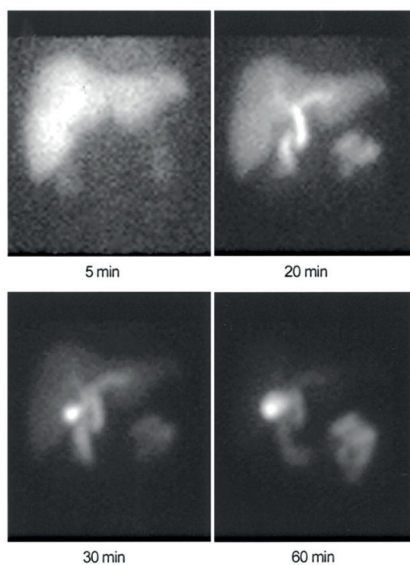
Normal hepatobiliary scintigraphy showing radiotracer flow into the small bowel at 20 minutes and into the gallbladder at 30 minutes. Images from SNMMI JNMT Journal.5
